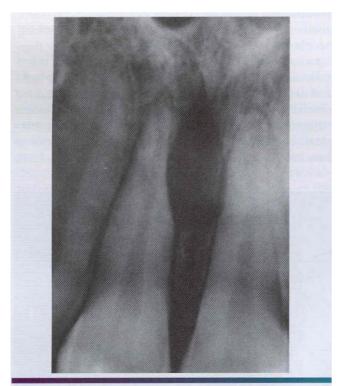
• Mesenchymal chondrosarcoma. Periapical radiograph showing a radiolucent lesion between the roots of the central incisors in a 29-year-old woman. The roots of the incisors show resorption. At surgery, the lesion was considerably larger than indicated on the radiograph. (Courtesy of Dr. Gary Baker.)
